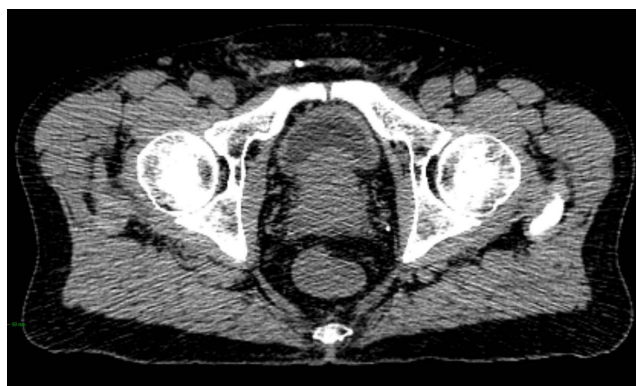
Transverse CT image of a male pelvis.
